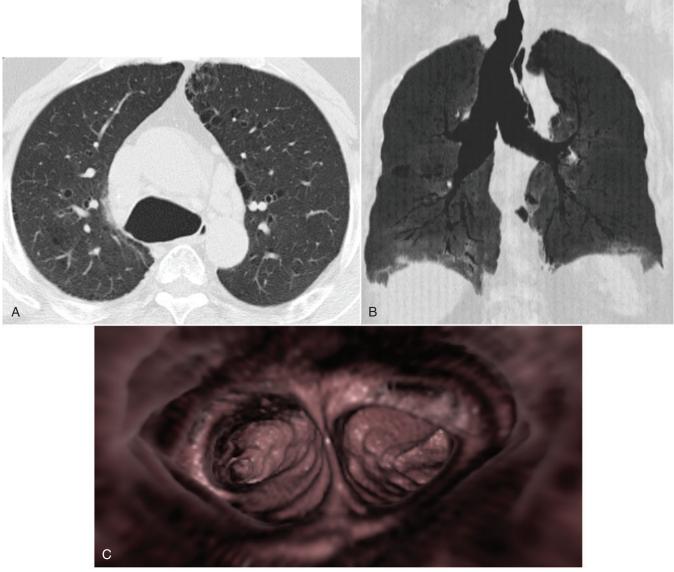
Use of Two- and Three-Dimensional Images for Visualization of the Trachea. Axial computed tomography (A) image demonstrates a massively dilated trachea in a patient with tracheobronchomegaly (Mounier-Kuhn). A coronally reformatted minimum intensity projection (minIP) image (B) allows for visualization of the entire trachea and main stem bronchi. A three-dimensional image (C) endoluminal view of the inferior trachea looking downward at the carina with the left and right mainstem bronchi located on each side of the carina. The three-dimensional image, termed *virtual bronchoscopy*, can aid the bronchoscopist in planning a bronchoscopic procedure.
